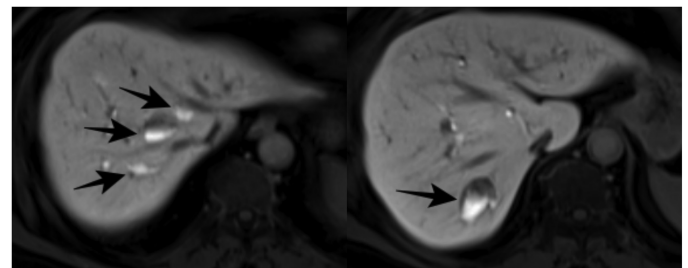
(A) High-signal cystic lesions (open arrows) in the liver observed on T2-weighted MRI. (B) Low-signal cystic lesions (filled arrows) in the liver observed on T1-weighted MRI. MRI, magnetic resonance imaging.
